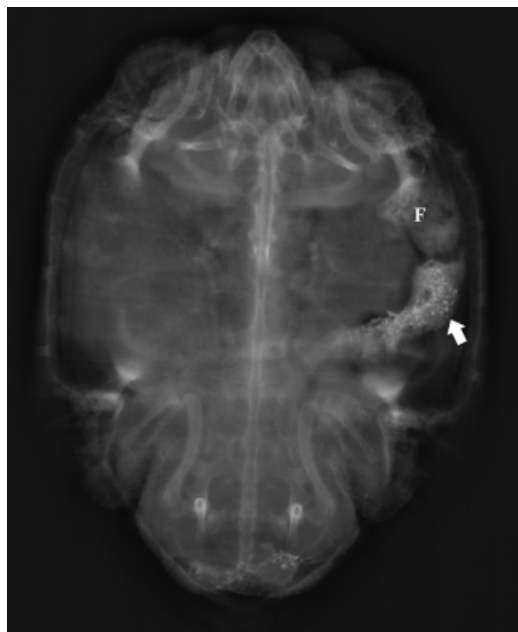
Dorsoventral radiograph 8 h after administration of Gastrografin[®]. Note the multiple granular opacities in the pylorus (white arrow) and the ingesta in the fundus (F).
